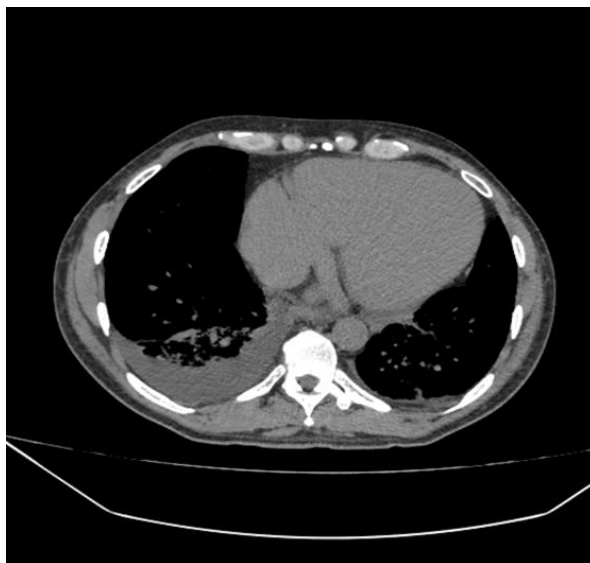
Chest CT scan: Marked increase in cardiothoracic ratio, indicating pericardial effusion in its posteroinferior recess measuring 31 mm. No lymphadenopathy within the pathological range. The esophageal tract and azygos arch are normal. Bone structures and soft tissues have typical CT characteristics
